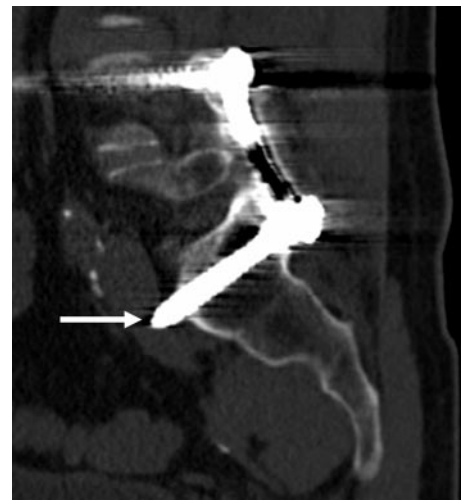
Penetration of the anterior sacral cortex in a 46-year-old man after lumbosacral fusion. Sagittal CT image shows that the inferior pedicle screw has exited the anterior cortex of the S1 segment and is impinging on the hypogastric vein (arrow).
